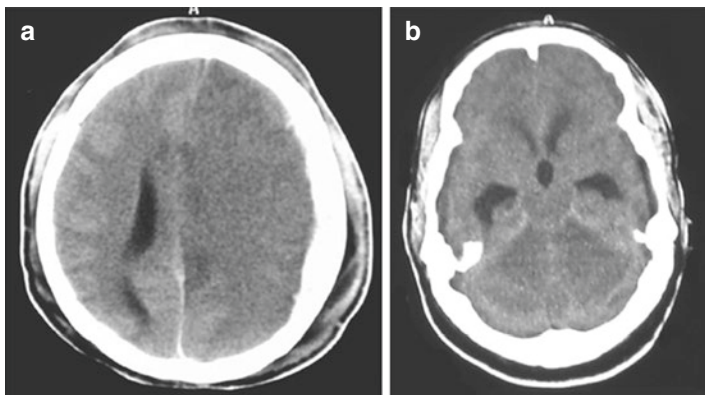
Non-contrast CT scan showing a massive left internal carotid territory infarct with swelling and midline shift (a) and an acute cerebellar infarct with hydrocephalus (b)
